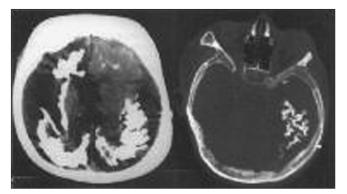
Rail road sign in computed tomography scan
